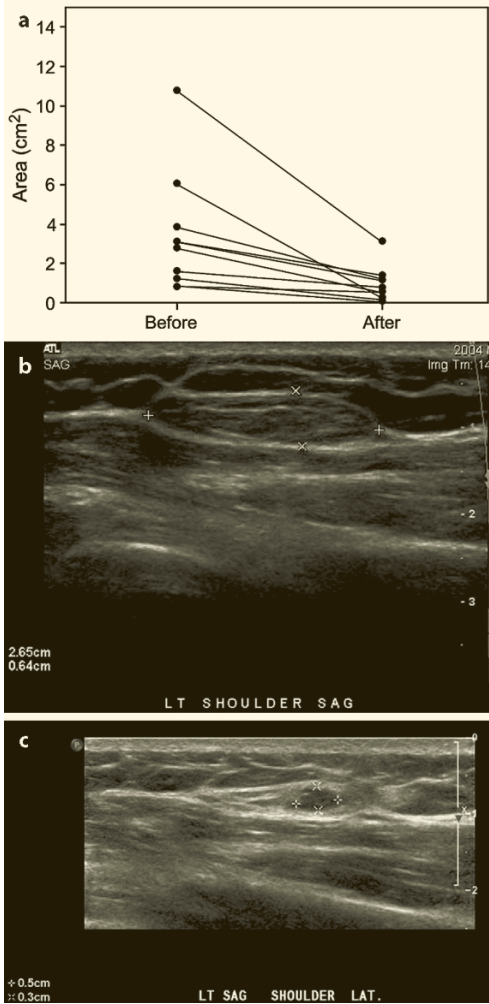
a–c. a Area (cm²) of 12 lipomas before and after an average of 2 subcutaneous deoxycholate injections. b Ultrasound of lipoma located on the shoulder, measuring 2.6–0.6 cm before treatment. c Same lipoma measuring 0.5×0.3 cm 4 months after the second and final injection. This Fig. 7. was obtained with the permission of Elsevier from Rotunda et al. (2005) [29]
